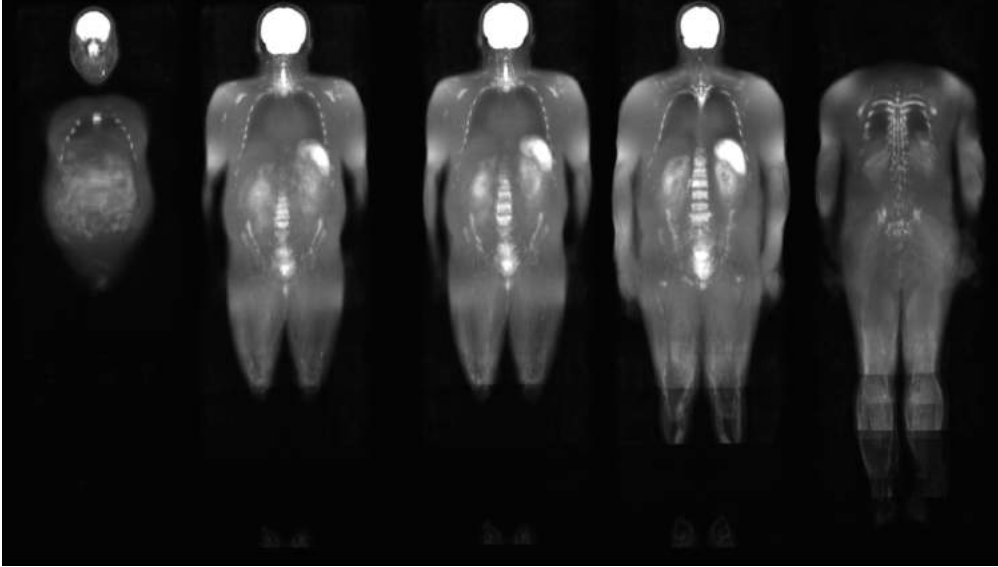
First male template image, built with nine DWI images and using the previously built mean image as the fixed image. These five representative coronal slices show, once again, very good alignments of the brain. The spleen shows a different shape, when compared with the mean male image, since the fixed image weighting is decreasing. Thus, the contribution of all available images is increasing, removing the bias of the fixed image.
